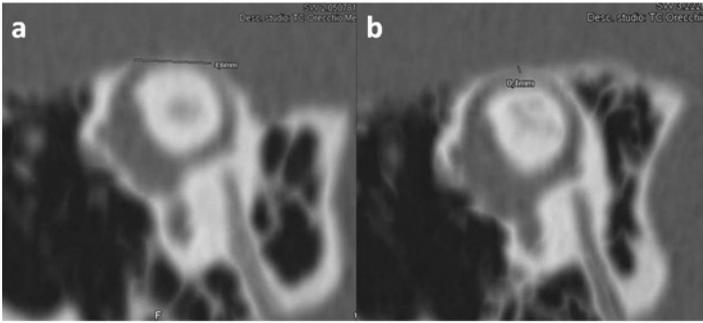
Temporal bones HRCT scans with reformatted images along Pöschl plane showing a dehiscence (a) and a normal (b) SSC. 1.a. In case of SCD, dehiscence size was measured. 1.b. In case of intact SSC, thickness of the bony roof was measured.
